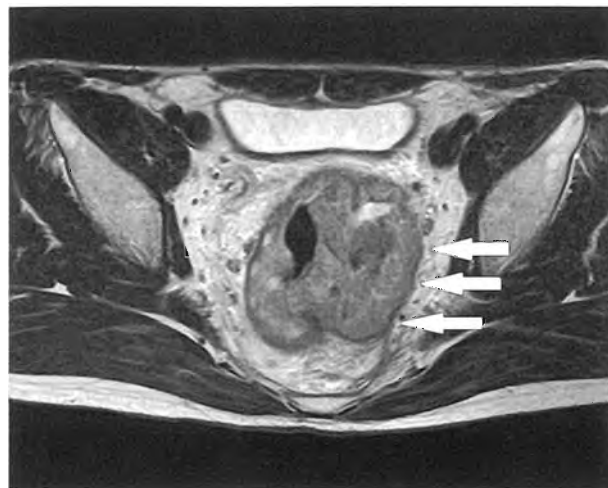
Case in which the tumor reached the perirectal fascia (MRI: T2WI)
